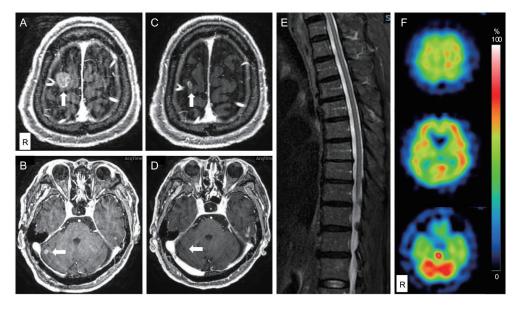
The imaging studies for the central nervous system. The contrast-enhanced magnetic resonance imaging (MRI) revealed brain metastases in the right parietal lobe (A) and cerebellum (B) six months after the initiation of chemo-immunotherapy. MRI showed no evidence of recurrent brain metastasis (C, D) or leptomeningeal carcinomatosis (E) when he developed paraneoplastic cerebellar degeneration. Brain perfusion scintigraphy revealed increased perfusion in the cerebellum compared to cerebral hemisphere (F).
